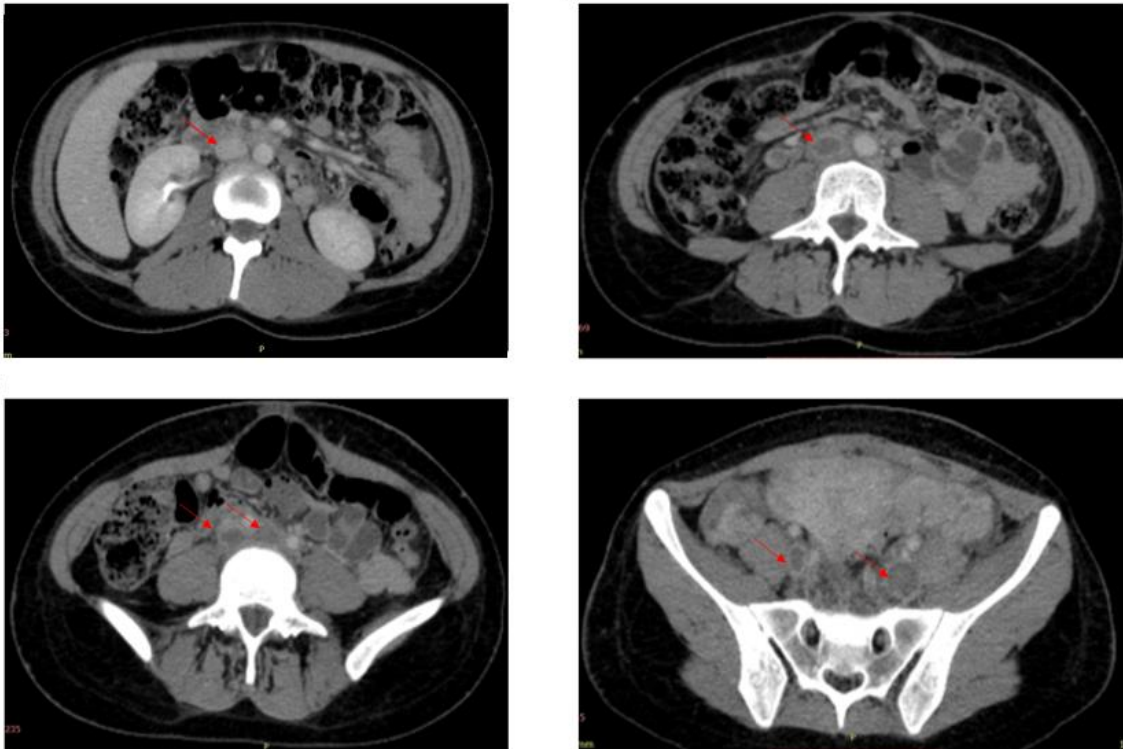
Contrast-enhanced CT of pelvis in the portal phase. Extensive venous thrombosis in the infrarenal portion of the inferior vena cava, in the external and internal common iliac veins, in the common femoral veins, bilaterally, in the right ovarian vein associated with edema in the adipose planes of the pelvic region.
